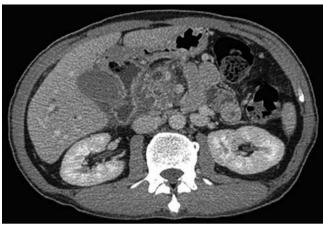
Computed tomography (CT) scan showing pancreatic mass at head and common bile duct, and pancreatic duct dilatation.
